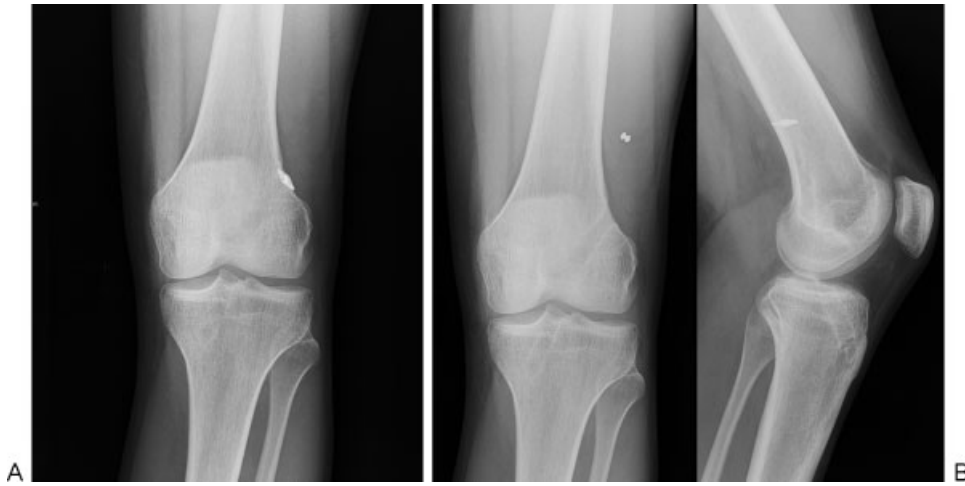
Standard anteroposterior and lateral knee radiographs of the involved knee. (A) Immediate postoperative radiographs showed proper placement of the XoButton as well as the femoral and tibial tunnels. (B) Six months after the operation, the implant was seen 39 mm more proximally than in (A).
